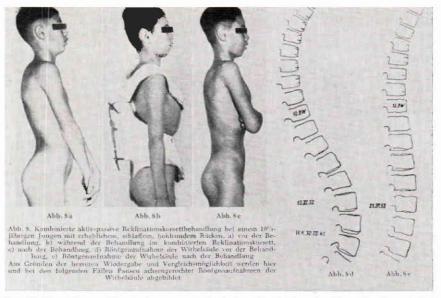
These three pictures give an example before the treatment, with reclination plaster corset, and finally the success of the treatment. On the right X-ray films show the spine before and after treatment.
